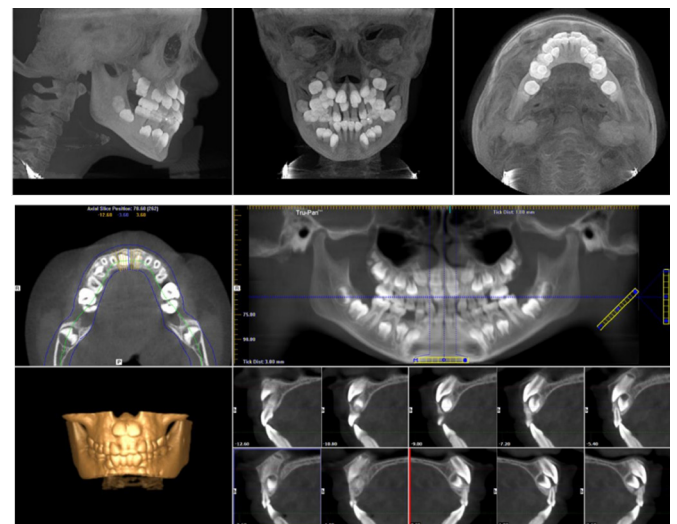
Cone Beam Computerized Tomography (CT) scan shows several supernumerary teeth.
